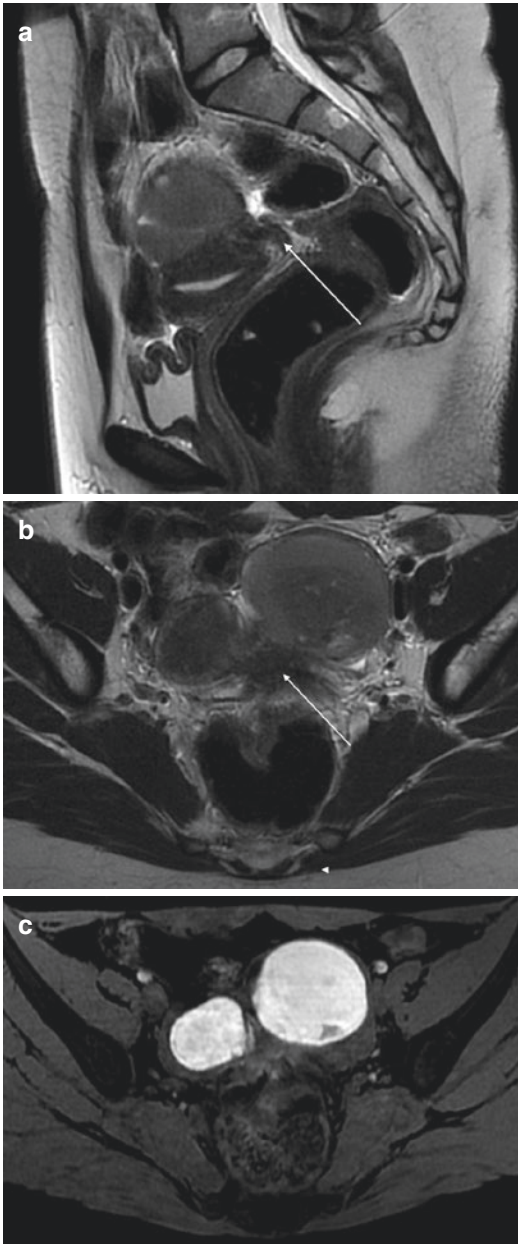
Endometrioma and torus endometriosis in a 16 year-old girl. (a) MR imaging: Sagittal T2-Weighted sequence. Thickening of the torus (*arrow*) in hyposignal. (b) MR imaging: Axial T2-Weighted sequence. Thickening of the torus in hyposignal (*arrow*) and bilateral endometrioma in ovaries adjacent to posterior wall of the uterus. (c) MR imaging: Axial T1-weighted fat-saturated sequence. Homogeneous and intense hypersignal T1-W of the endometrioma
